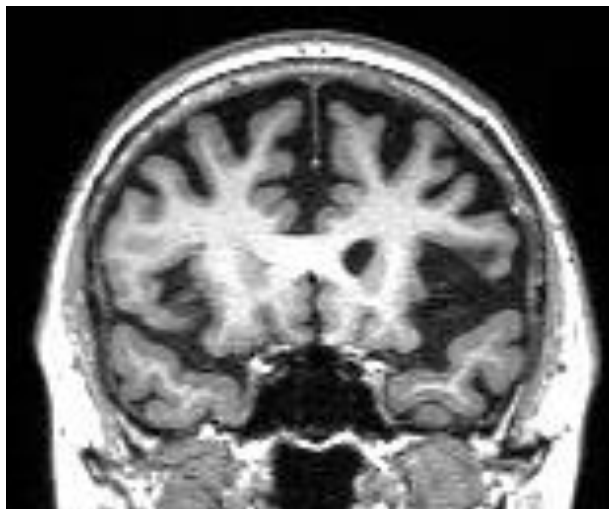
Coronal volumetric T1-weighted MRI of a patient with nfvPPA. The scan shows typical asymmetric atrophy of left insula and opercular inferior frontal gyrus. The left hemisphere is on the right side.
